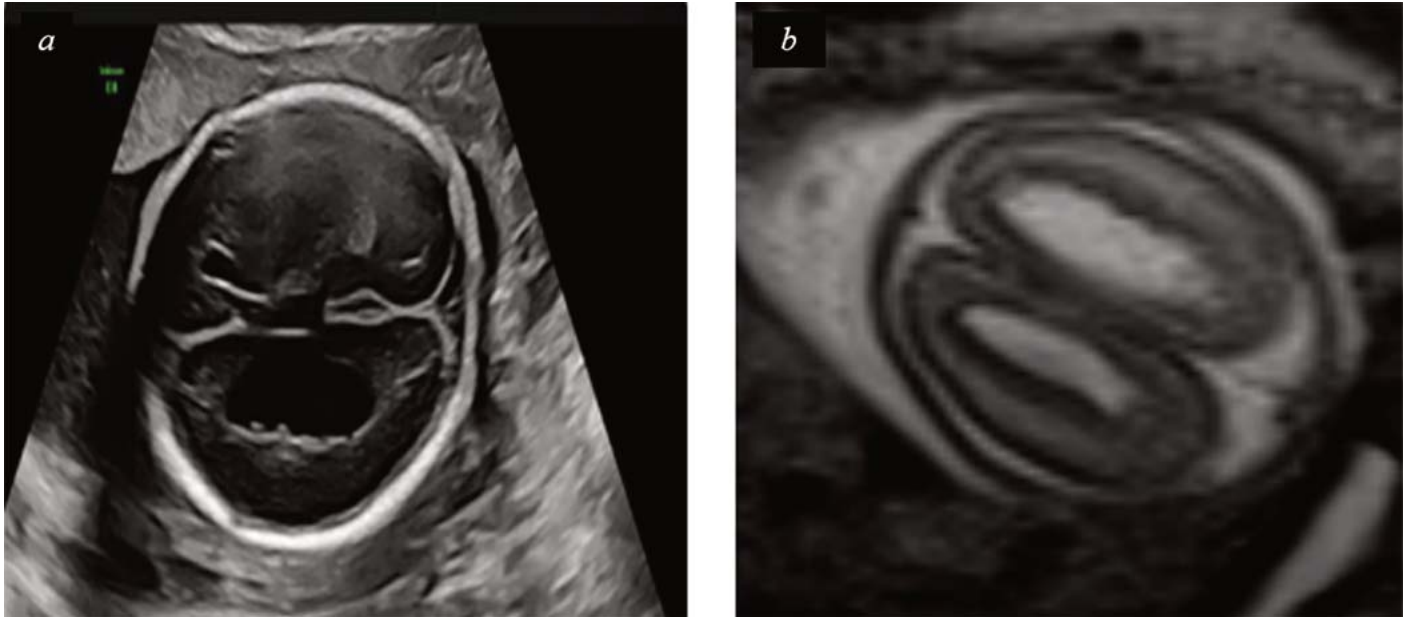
A fetus with heterotopia on antenatal ultrasound at 22 gestational weeks with a missense mutation of the *FLNA* gene (a) Axial image performed at 22 gestational weeks showing heterotopia (b) Brain MRI scan of the same fetus, axial section.
